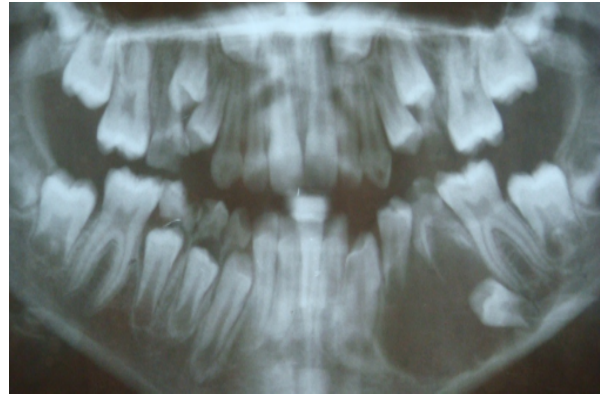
Primary panoramic radiograph
